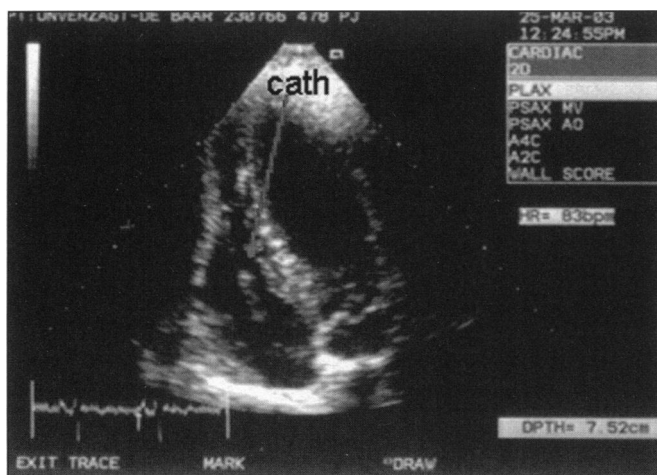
Echocardiographic frame depicting the entrapped catheter (cath) in the right atrium crossing the tricuspid valve lodging in the right ventricle.
